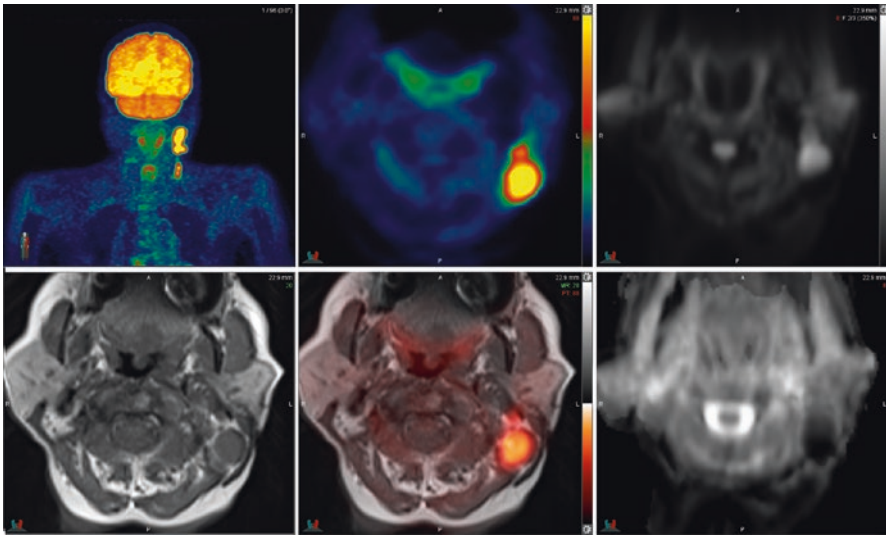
77-year-old female with Hodgkin lymphoma. FDG PET/MRI demonstrates intense uptake in left cervical lymphadenopathy. Lymph node margins are well defined on axial HASTE MR (lower left frame), corresponding DW imaging demonstrates high signal (upper right frame) in left cervical adenopathy with corresponding low signal (dark) on ADC images (lower right frame)
